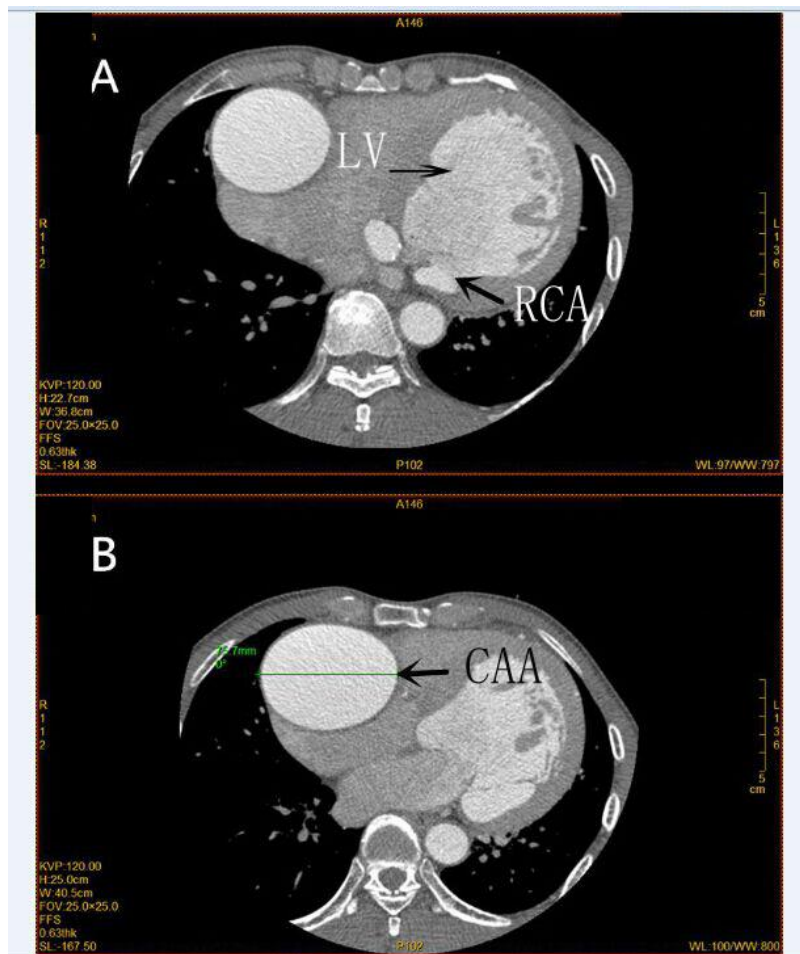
Axial computed tomography (A): RCA with connection to LV, the arrowhead points the fistula; (B): the maximum diameter of 75.7 mm of CAA (arrow)
